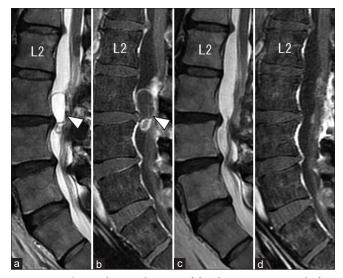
The mid-sagittal view of lumbar MR images before (a, b) and after (c, d) the second surgery. T2-weighted (a) and Gd-enhanced T1-weighted (b) images showing tumor recurrence at the levels of L3-4 (white arrowhead). Postoperative T2-weighted (c) and Gd-enhanced T1-weighted (d) images showing the total removal of the recurrent tumor.
